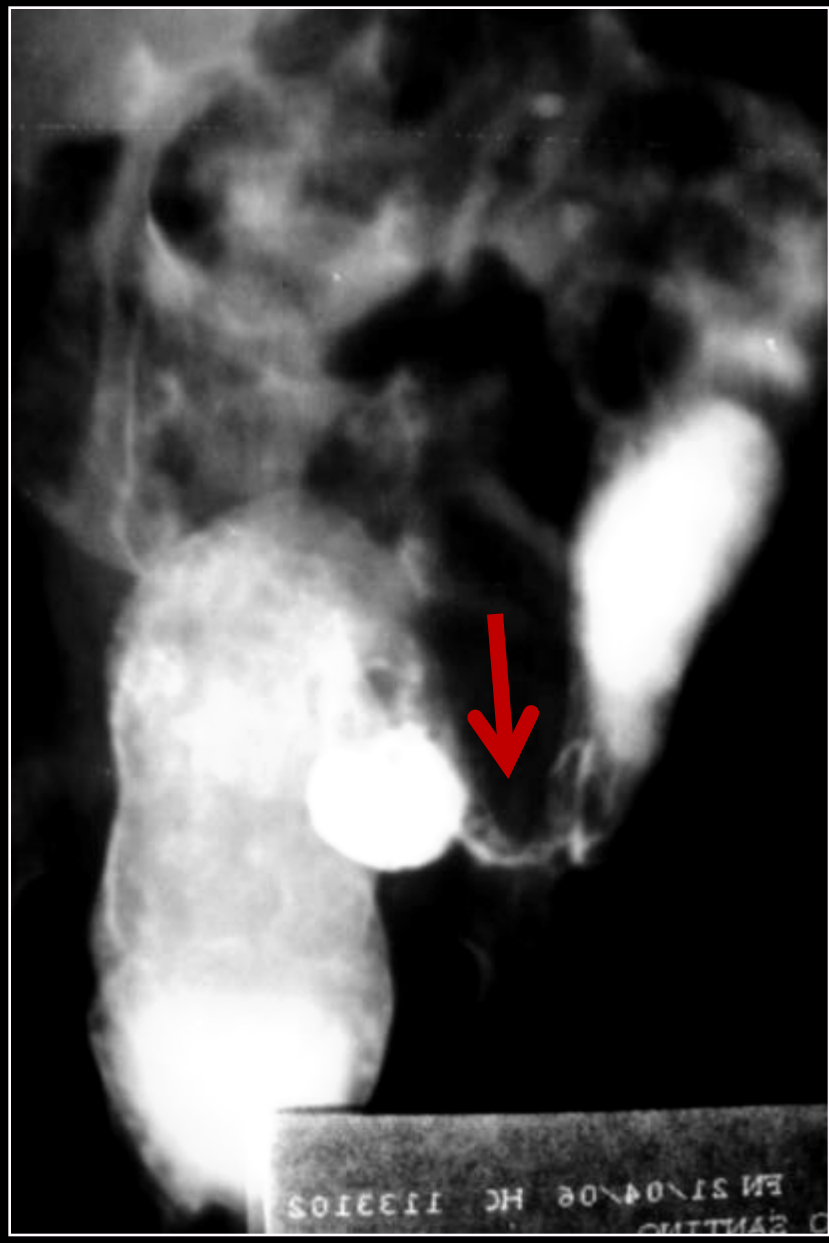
(A) The radiographic findings revealed an irregular air distribution and pneumatosis intestinalis (in the lower right abdomen). (B) The contrast enema study (barium enema) shows a stricture (arrow) in the proximal sigmoid colon consistent with a stricture following necrotizing enterocolitis (case 11).
